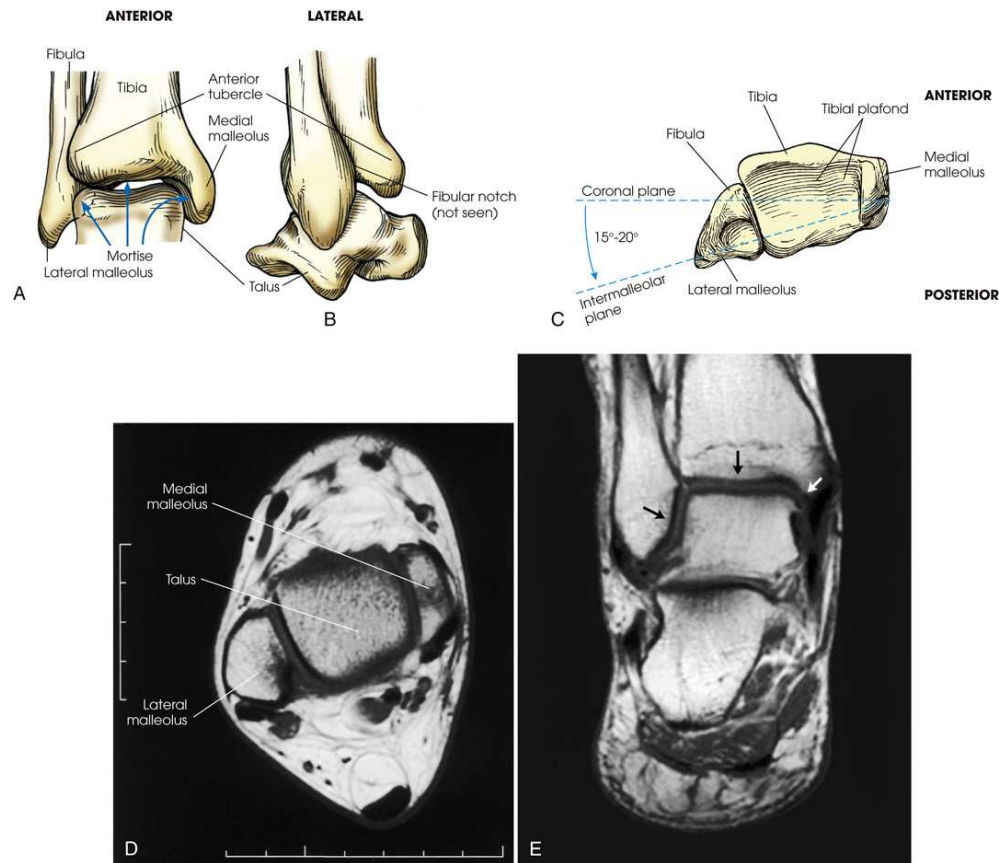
(A) Right distal tibia and fibula in true anatomic position. Mortise joint and surrounding anatomy. Note slight overlap of anterior tubercle of tibia and superolateral talus over fibula. (B) Lateral aspect showing fibula positioned slightly posterior to tibia. (C) Inferior aspect. Note lateral malleolus lies more posterior than medial malleolus. (D) MRI axial plane of lateral and medial malleoli and talus. Lateral malleolus lies more posterior than medial malleolus. (E) MRI coronal plane of ankle clearly showing ankle mortise joint (arrows).
